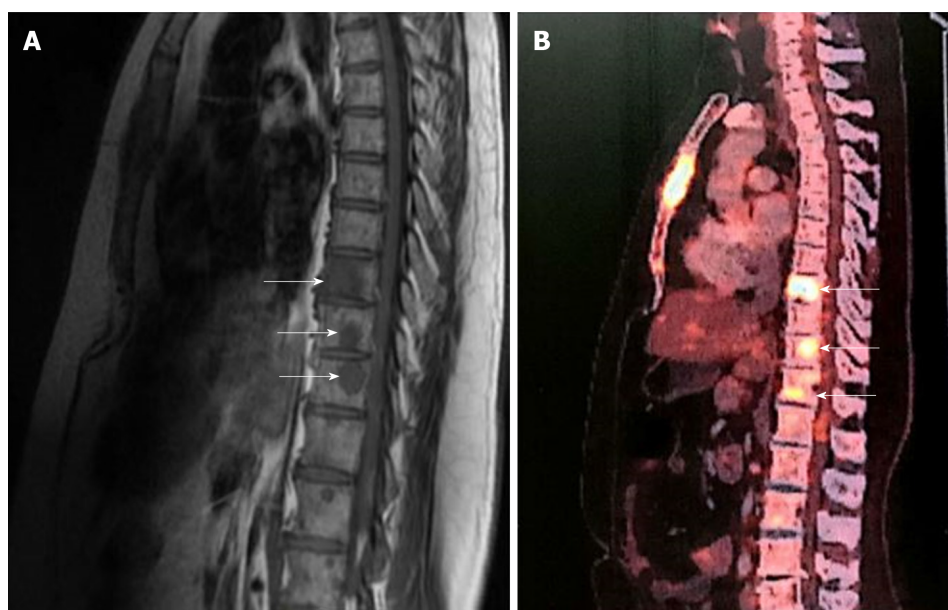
Magnetic resonance imaging and positron emission technology scan. A: Magnetic resonance imaging showing multiple osteolytic lesions (arrows); B: Positron emission technology scan showing multiple osteolytic lesions with high fluorodeoxyglucose avidity (arrows).
